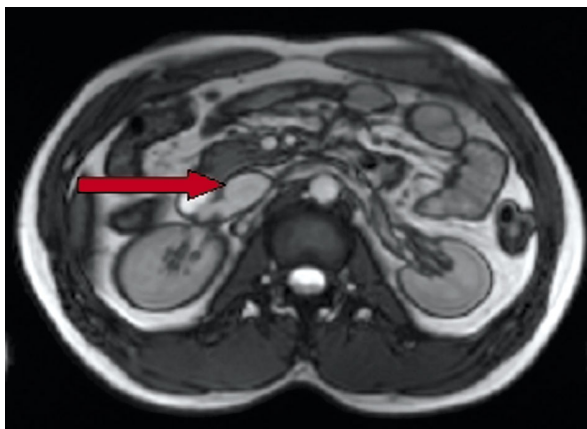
Magnetic resonance imaging confirmed the size of the lesion and its location in the upper pole of the right adrenal gland, although it suggested location outside the tumour
